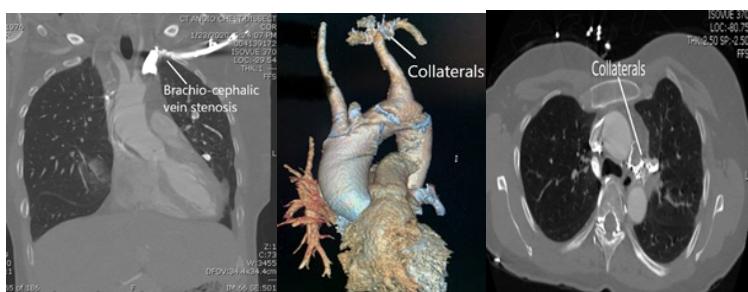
2D and 3D CT angiogram of the chest showing the brachiocephalic vein stenosis with extensive collateralization.
